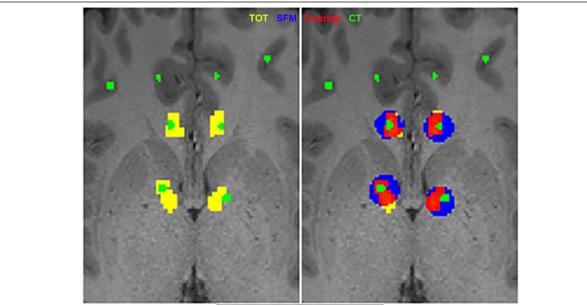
Generation of Imaging Defined Parameter Set. Left panel: CT and sEEG electrodes are shown in green. The tractography optimized target (TOT) for both SCC and VC/VS DBS targets is shown in yellow. Right panel: The blue regions are SFMs for a particular stimulation parameter set, and their overlap with the TOT is shown in red.
